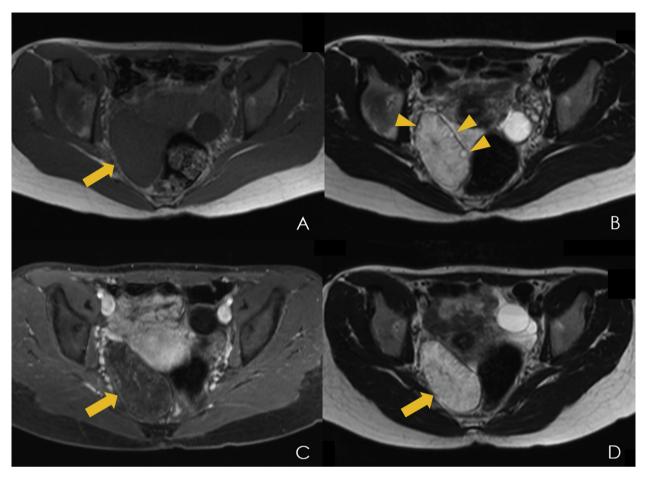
Magnetic resonance imaging of the pelvis in a 32-year-old woman with lower abdominal pain. (A) The axial T1-weighted image on the first visit shows the enlarged right ovary (arrow) with isointensity. (B) The axial T2-weighted image on the first visit shows the enlarged right ovary with high intensity and peripheral small cysts (arrowheads). (C) The postcontrast axial T1-weighted image on admission reveals ovarian torsion and a lack of obvious enhancement (arrow). (D) The axial T2-weighted image on admission shows the enlarged ovary has increased and the peripheral small cysts are less clearly visible (arrow).
